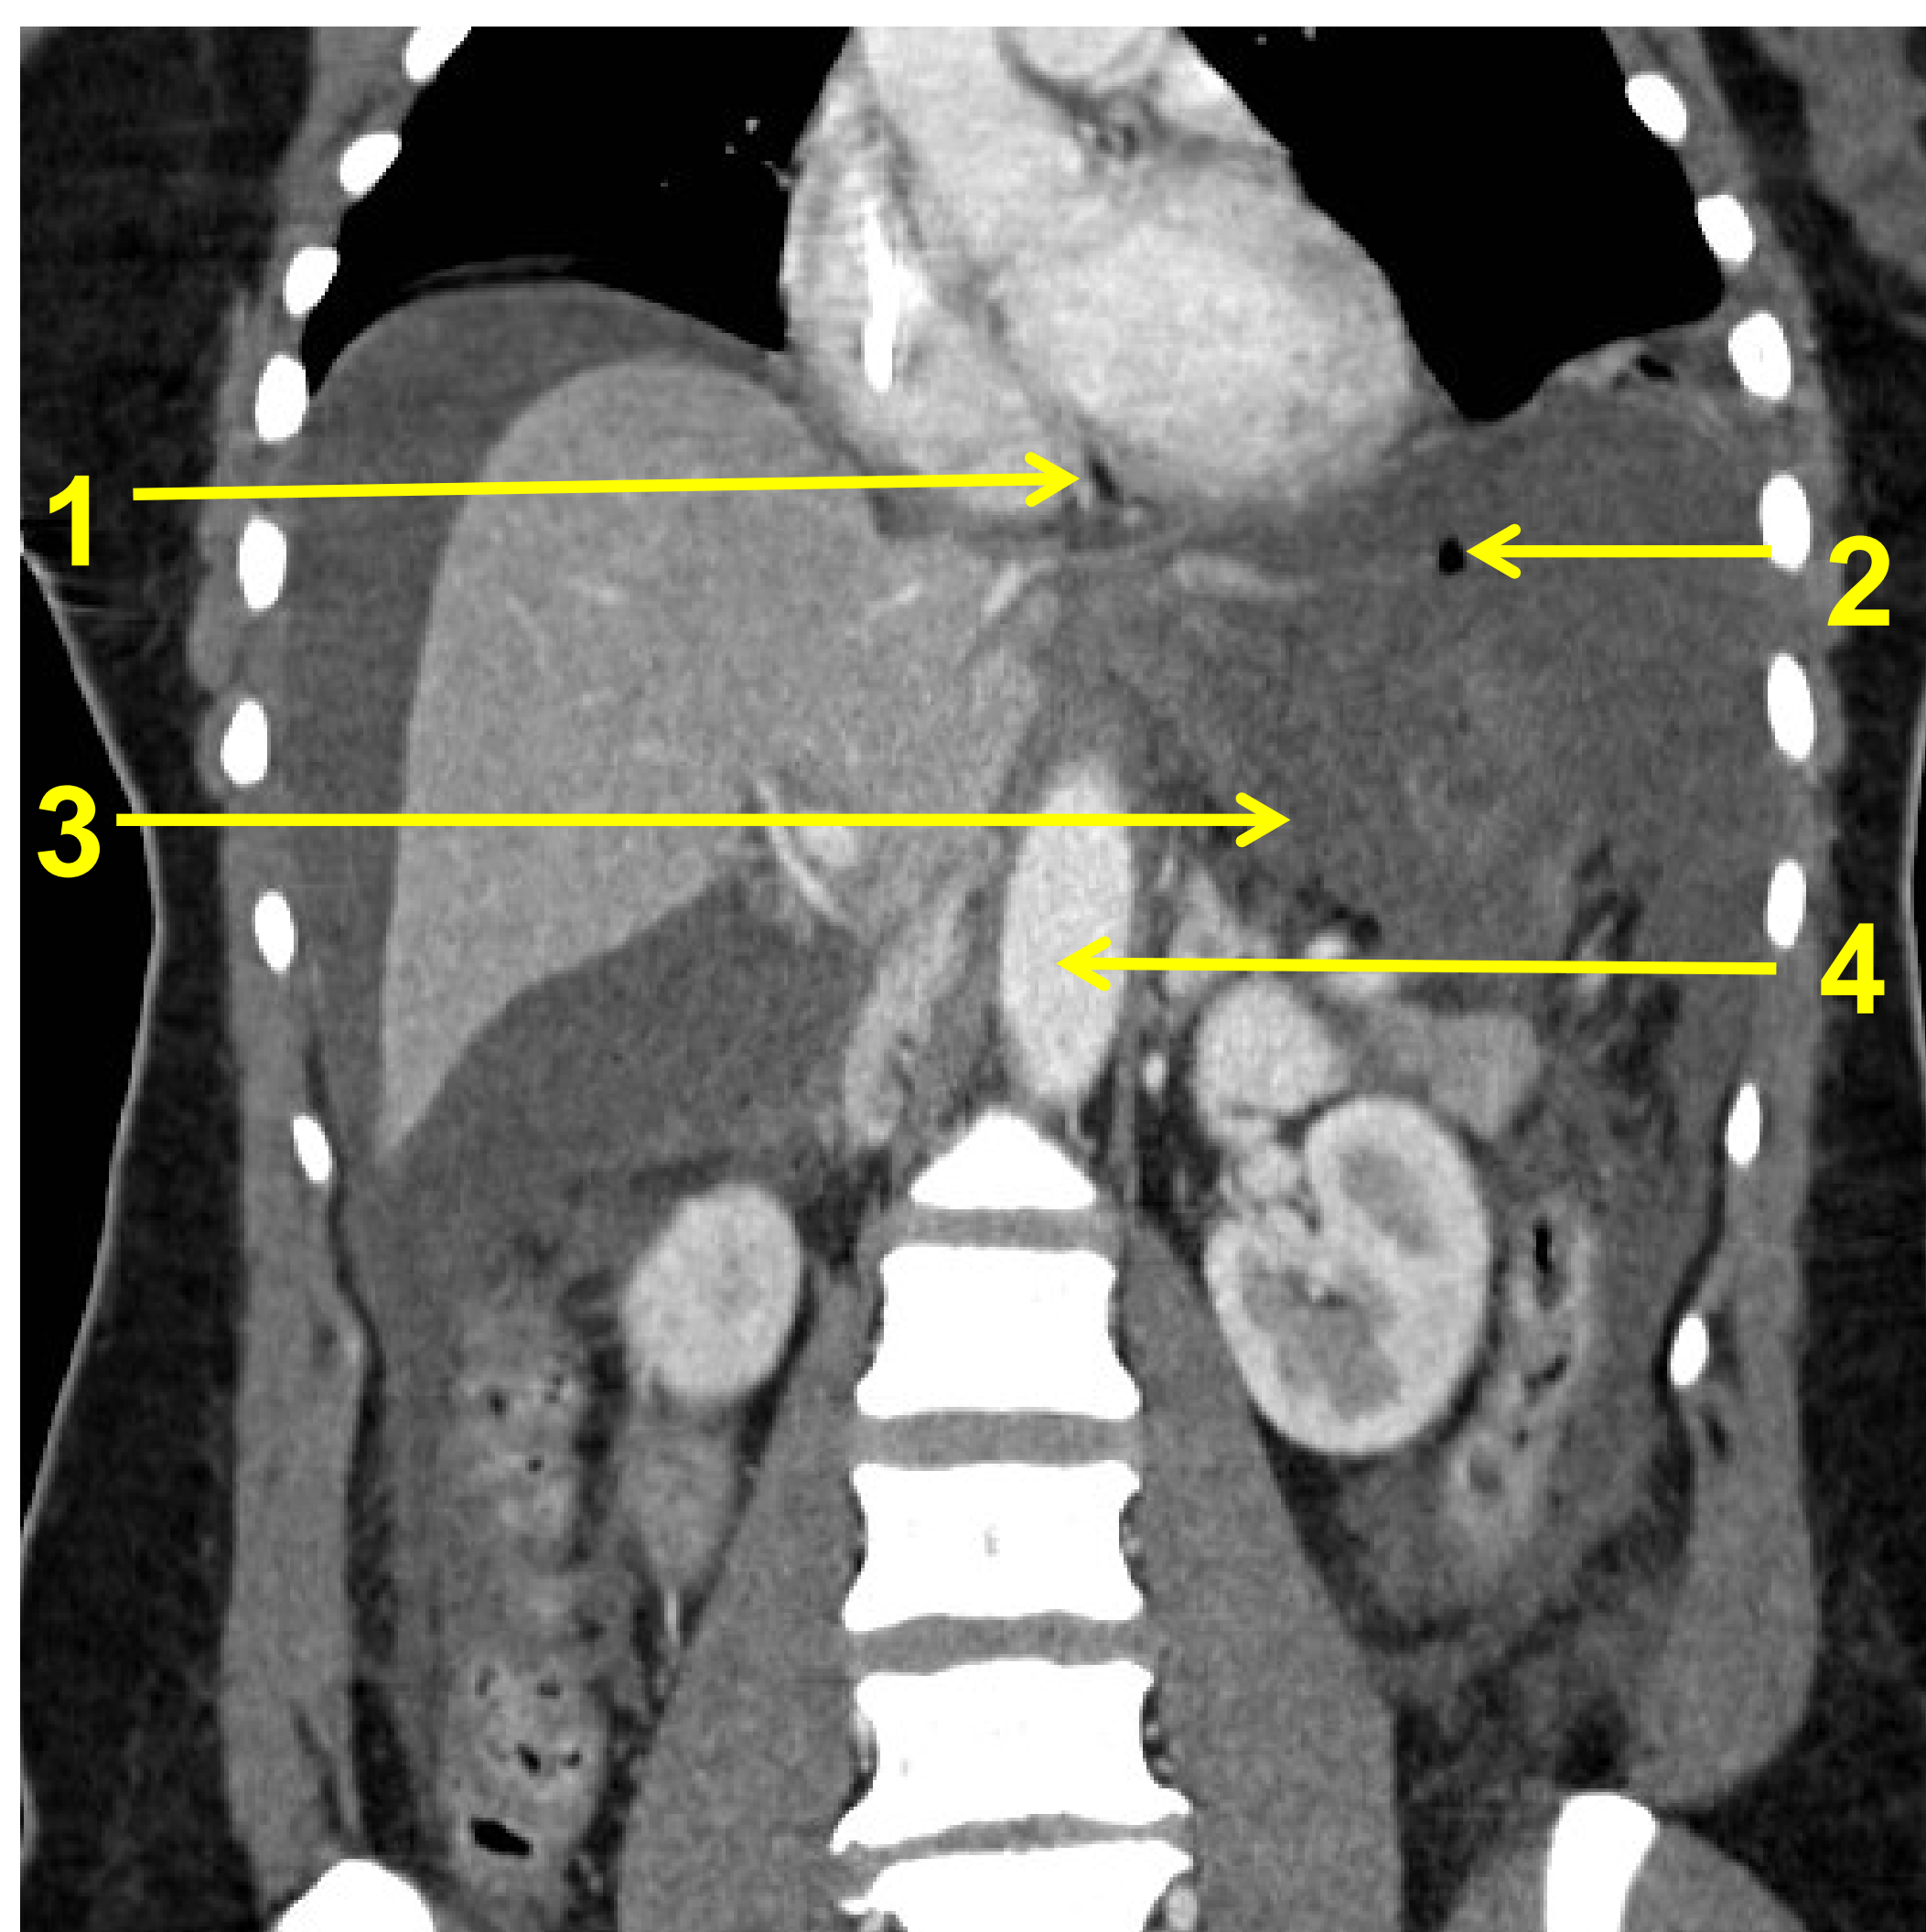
CT coronal section of abdomen
